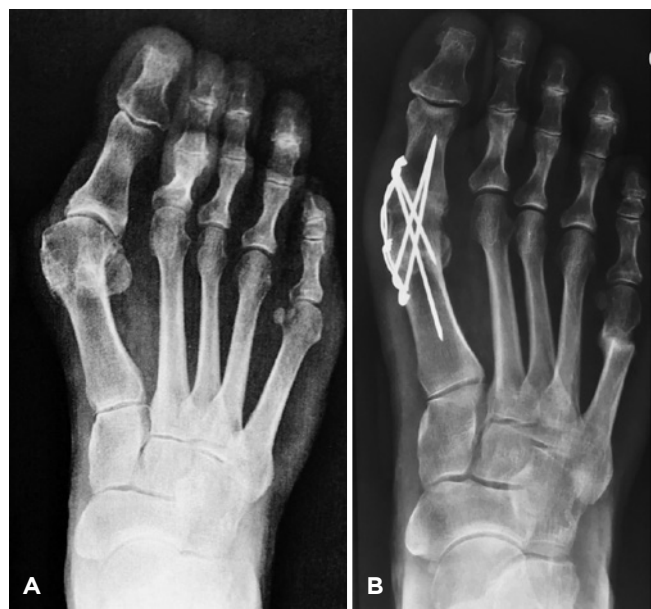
A. Pre and B. Postoperative radiographs.
